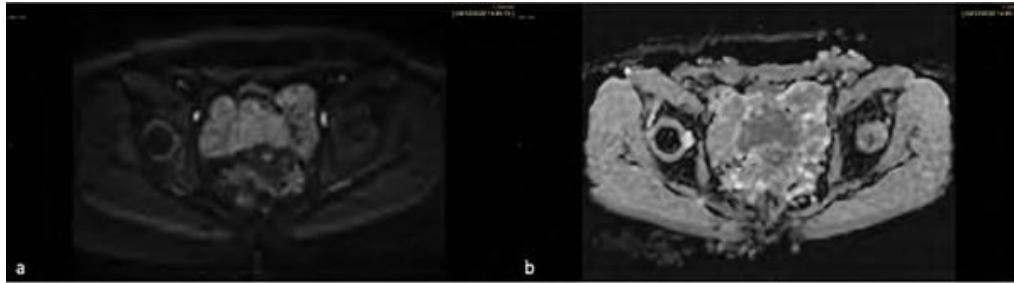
Diffusion weighted imaging (DWI) and ADC (apparent diffusion coefficient) map. The intermediate signal intensity at high-b value DWI (a) without significantly low signal intensity on ADC map (b) along with the other features helped us direct our diagnostic hypothesis toward lesions of benign character not characterized by inter-cellular component.
